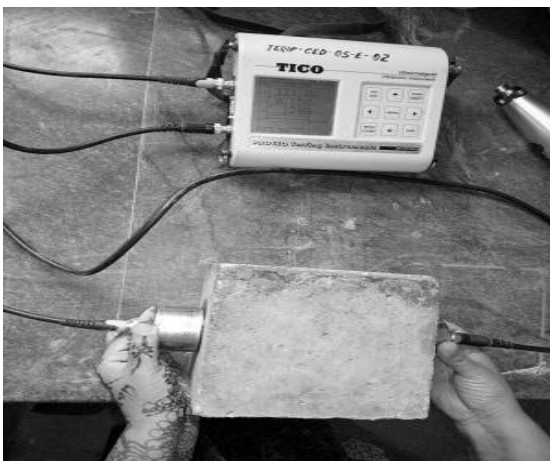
Test Setup for Ultrasonic Pulse Velocity
